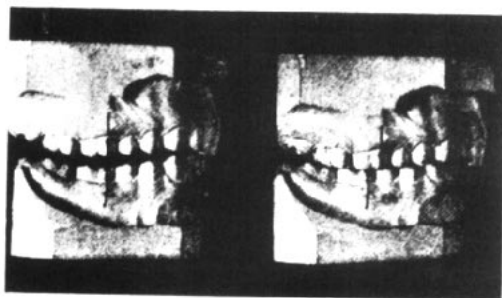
Cephalometric x-ray tracings and casts related at rest position and in occlusion. Note the posterior-superior path of closure.
